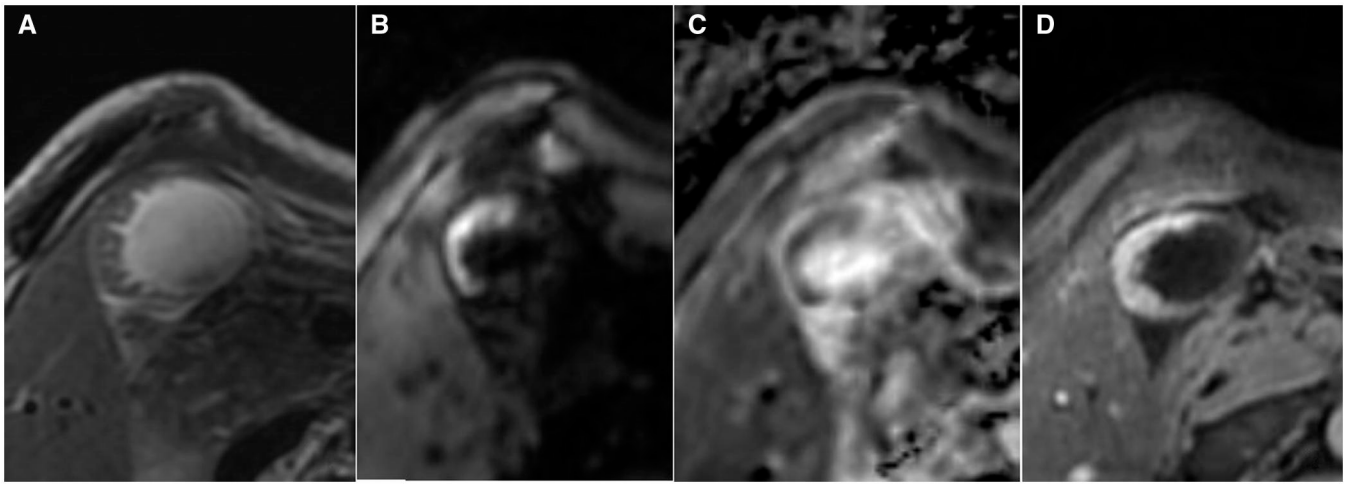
MRI images of the case. (A) Axial T2WI shows “comb-tooth” like thickening in the right posterior wall of the body and the bottom of gallbladder, with iso-signal intensity and clear edge. (B) The lesion was hyper-signal intensity on DWI. (C) The lesion was hypo-signal intensity on ADC map, with ADC values ranging from 1.1×10^{-3} to 1.7×10^{-3} mm^2/s . (D) Arterial phase of DCE-MRI shows obvious enhancement of the lesion.
